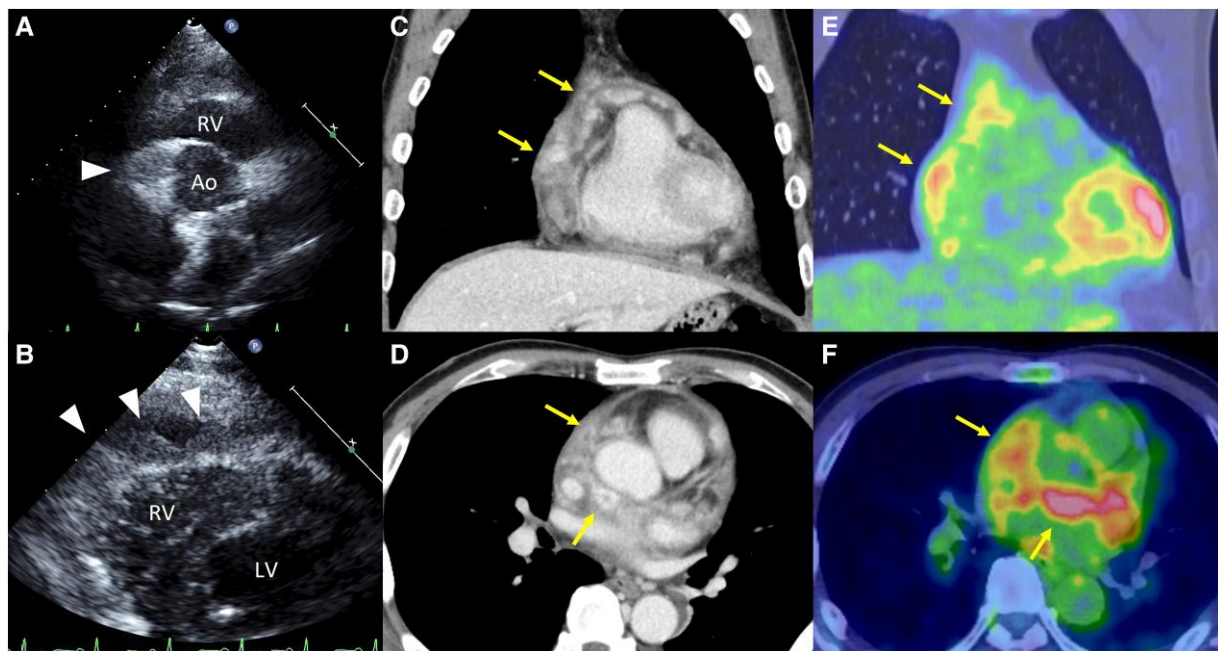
(A and B) Transthoracic echocardiography shows hyperechoic lesion around the aortic root (A, arrowhead) and multiple nodules on the visceral pericardium (B, arrowheads). (C and D) Contrast-enhanced computed tomography shows diffuse thickening of pericardium, with a small amount of pericardial fluid present. Contrast-enhanced nodules are visible along the visceral pericardium and in the soft tissue around the aortic root, coronary arteries, and on the dorsal aspect of the left atrium (arrows). (E and F) ^{18}F -fluorodeoxyglucose positron emission tomography/computed tomography. ^{18}F -fluorodeoxyglucose uptake coincident with mass and nodules, indicating active inflammation (arrows). Ao, aorta; LV, left ventricle; RV, right ventricle.
